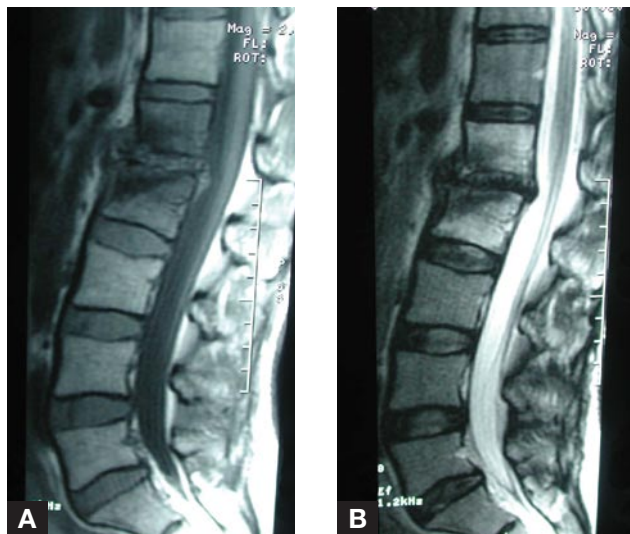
Four-month repeat T₁-weighted (A) and T₂-weighted (B) magnetic resonance imaging scans show progression of disc space changes with some collapse into kyphosis.
